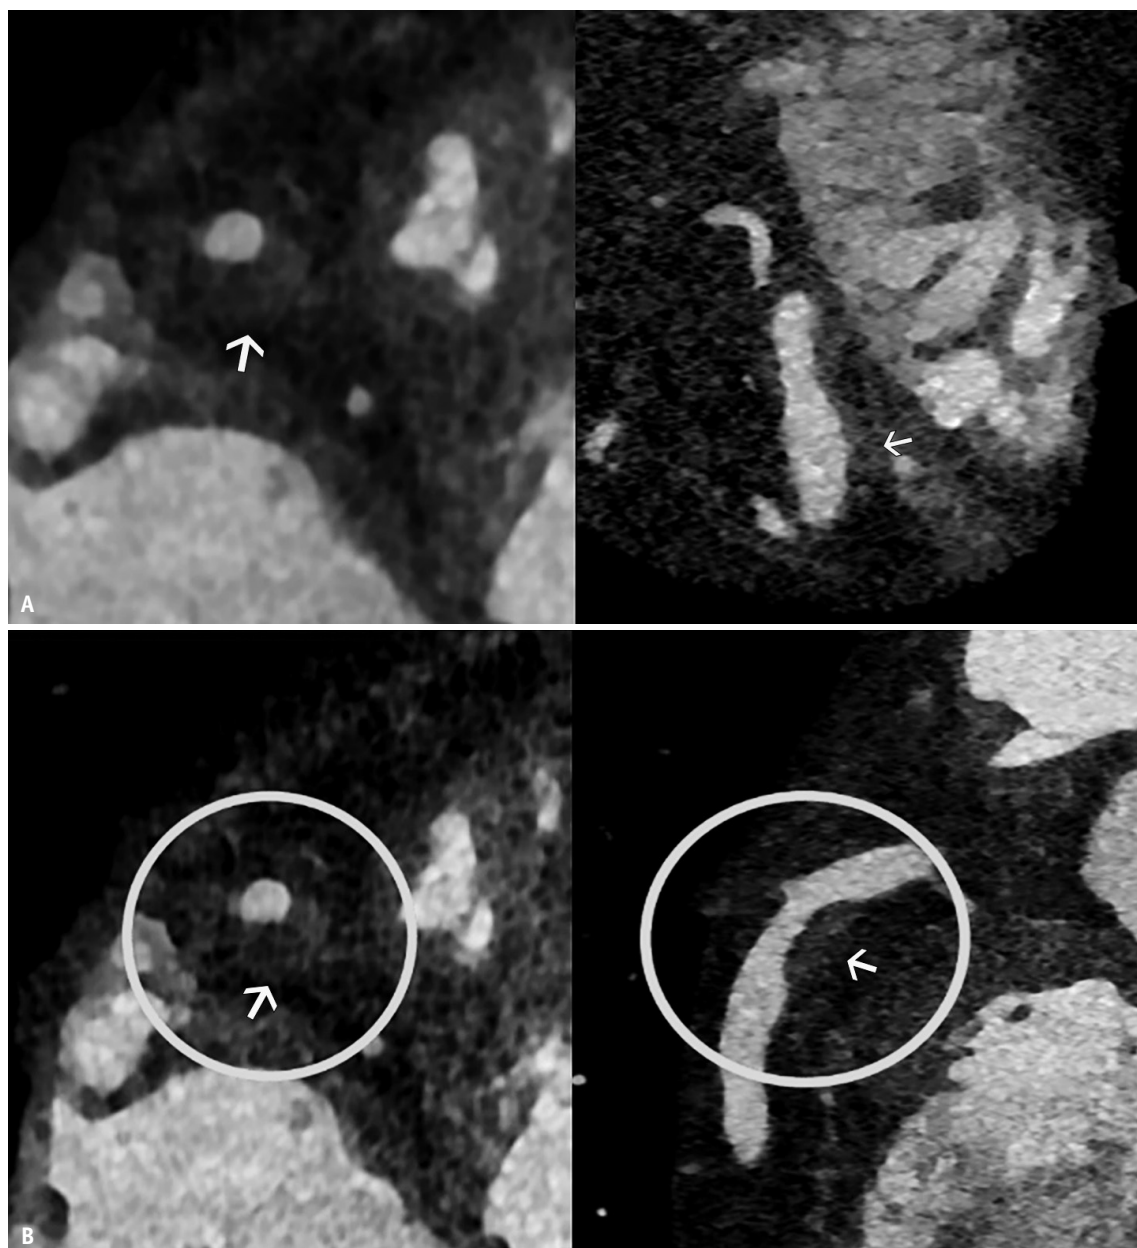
Vessel wall and plaque characterization. A: Short-axis and axial oblique CTA from an energy-integrating detector-CT in a 61-year-old female shows a non-calcified plaque in the mid right coronary artery with positive remodeling (arrows), causing mild stenosis. B: CTA from photon-counting CT in the same patient shows improved plaque definition with clear visualization of a central low-attenuation lipid core (arrows), indicating a high-risk plaque prone to rupture. CTA = CT angiography
